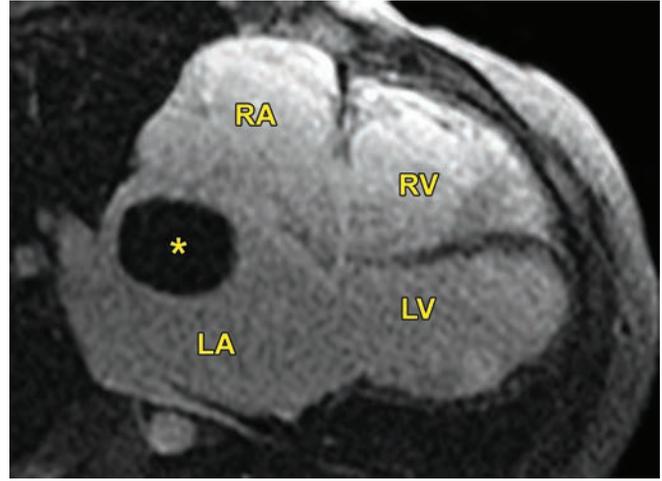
Magnetic resonance imaging (MRI). Asterisk shows a large mass in the left atrium.
